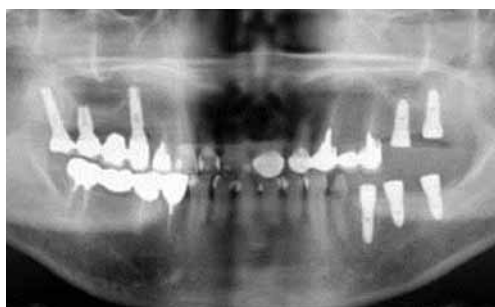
Postsurgical panoramic radiograph. Adequately positioned implants and 3-5mm high dome-shaped grafted bone around the implant apices are seen.
